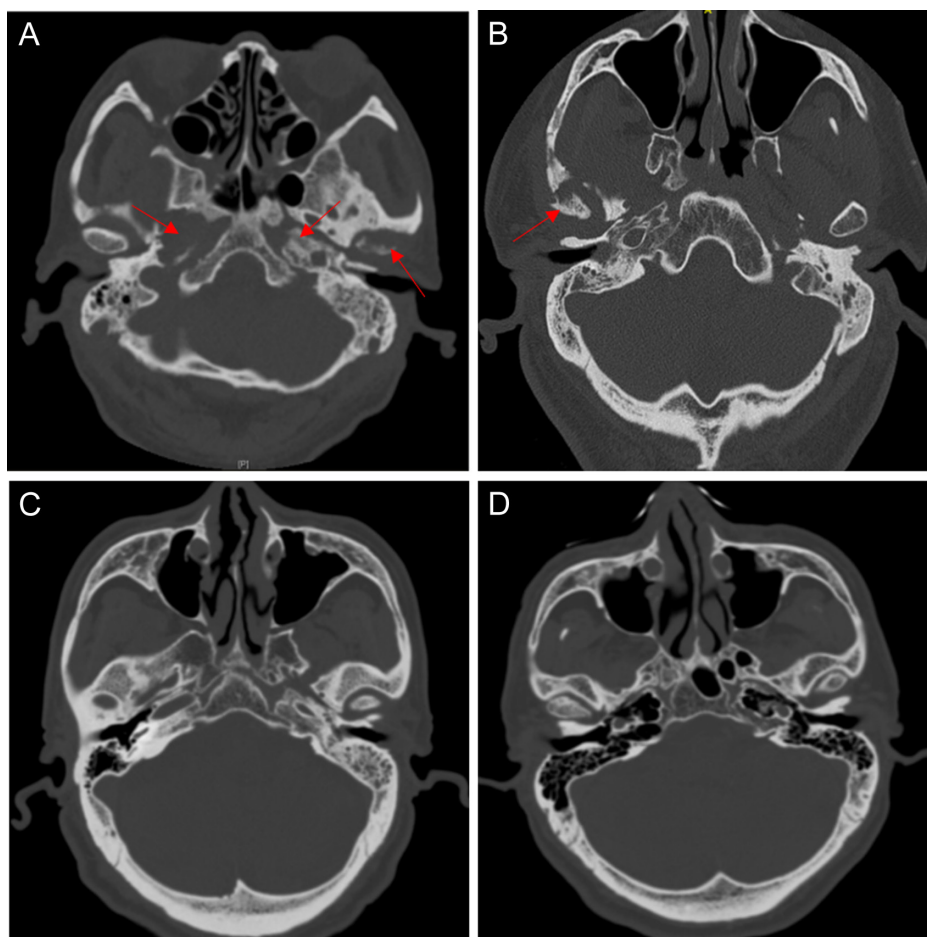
A-D. Computed tomography images of case 1 (A), case 2 (B), chronic suppurative otitis media (C), and normal structures of the temporal bone (D), respectively. Arrows in A and B show obvious bone destruction.
